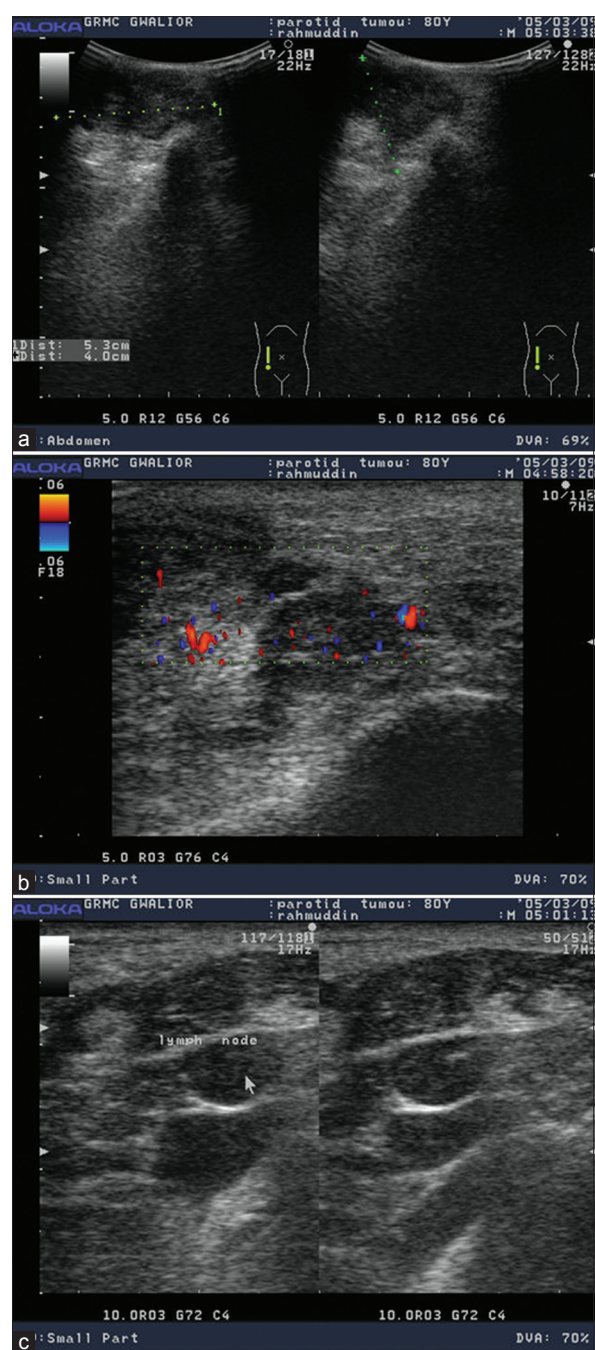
(a-c) Grayscale and color Doppler ultrasonography image of mucoepidermoid of right parotid gland with cervical lymphadenopathy
